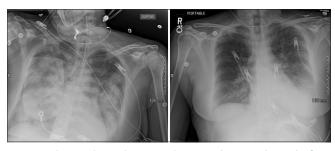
Chest Radiography. Pre and post-intubation radiographs from original outside hospital admission
